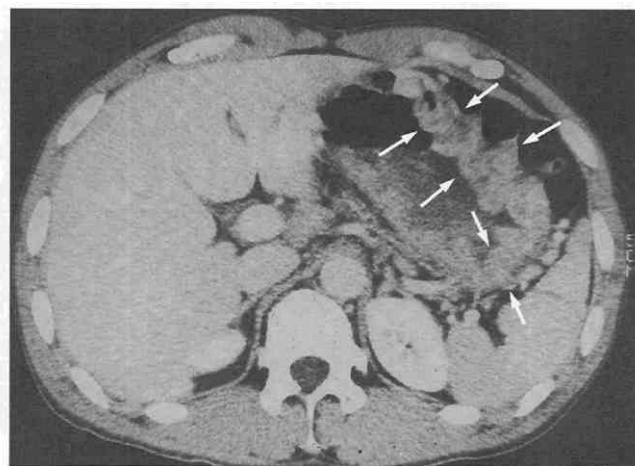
Ménétrier's disease of the stomach. CT scan shows marked thickening (arrows) of the gastric rugal folds along the greater curvature of the stomach.
